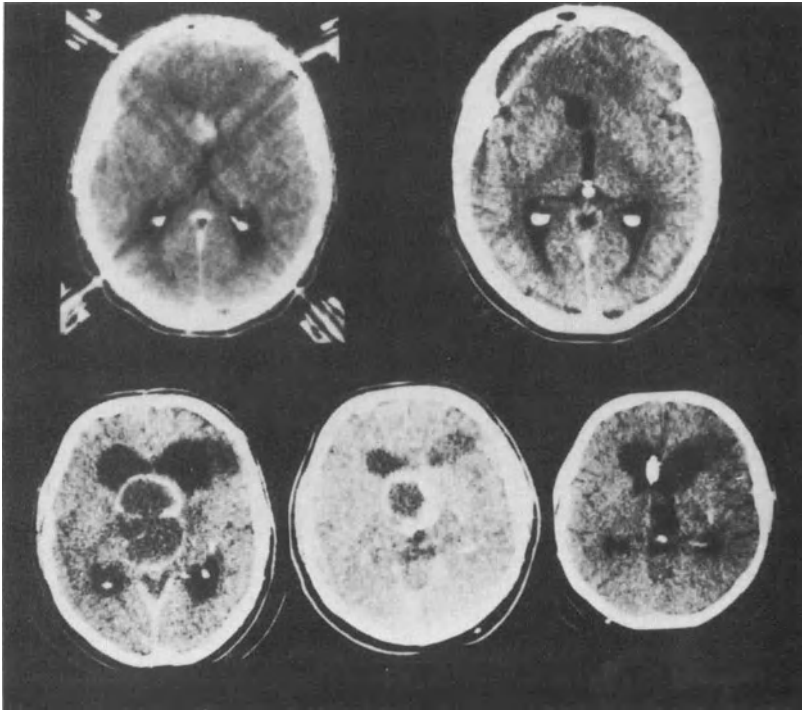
Preoperative and postoperative CT scans in intraventricular lesions: top—meningioma; bottom—large ganglioglioma removed in two stages.
